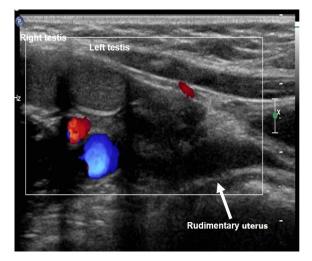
Ultrasound showing two separate gonadal structures both located in the right inguinal channel.
